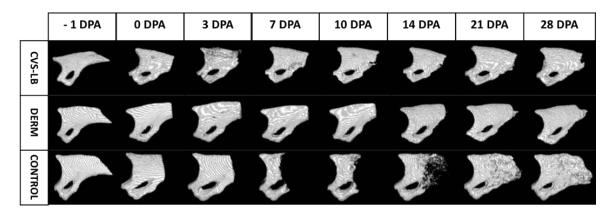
μ CT Scans of Treated and Control Digits. These scans range from pre-amputation (-1 DPA) to 28 DPA and show the progression of degeneration/regeneration in 3 separate digits that have been treated (CVS-LB or Dermabond) or left untreated to serve as controls.
